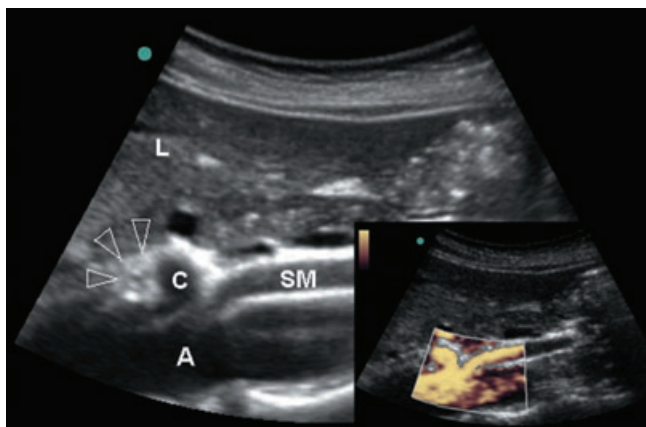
Sonoanatomy of celiac plexus block (long axis to blood vessels). A, aorta; C, celiac trunk; L, liver; arrowhead, celiac plexus. In inset—color Doppler.
